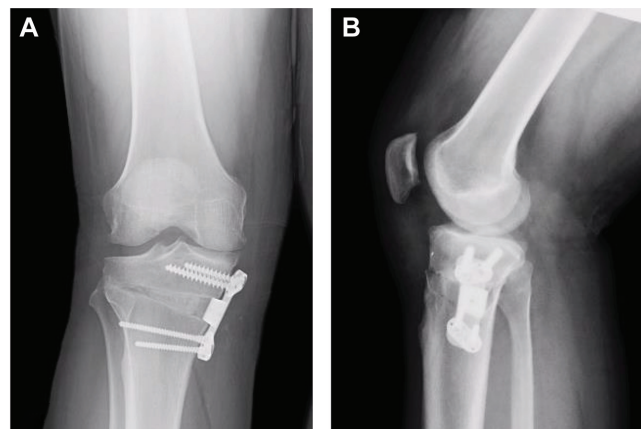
(A) Postoperative anteroposterior and (B) lateral knee radiographs after high tibial osteotomy.
